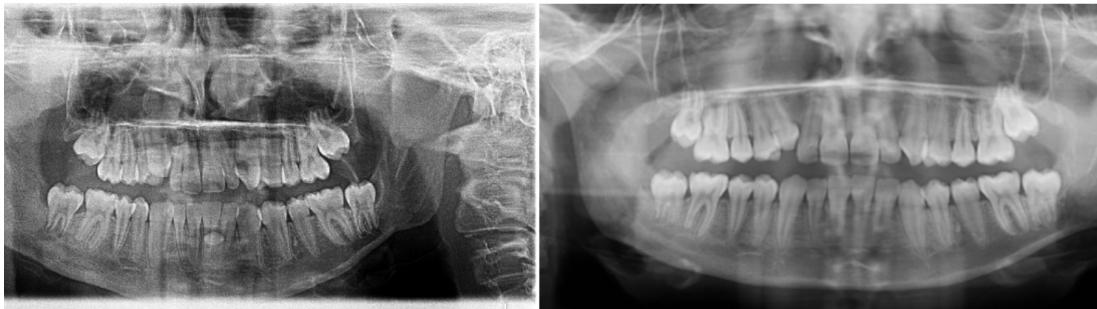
Panoramic radiograph showing the no findings of periapical periodontitis or fractures
